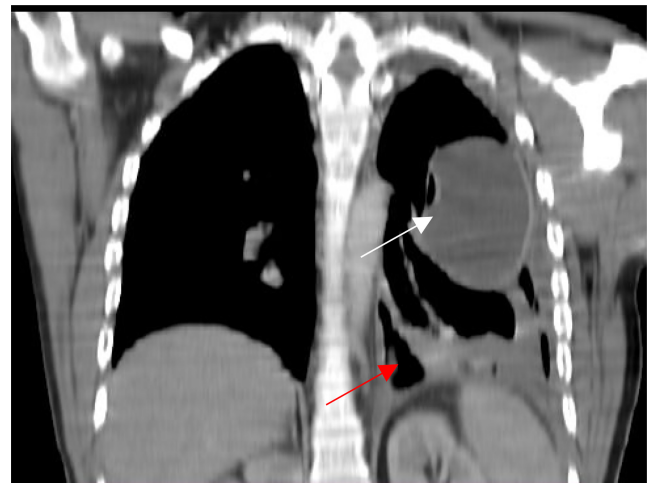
CT with Coronal section scan shows of the ruptured cyst (red arrow). And the intact cyst (white arrow).
